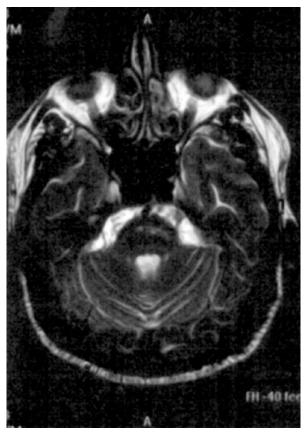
Axial Gd-MRI scan of Case 1 showing ischaemic lesions in brainstem area.
